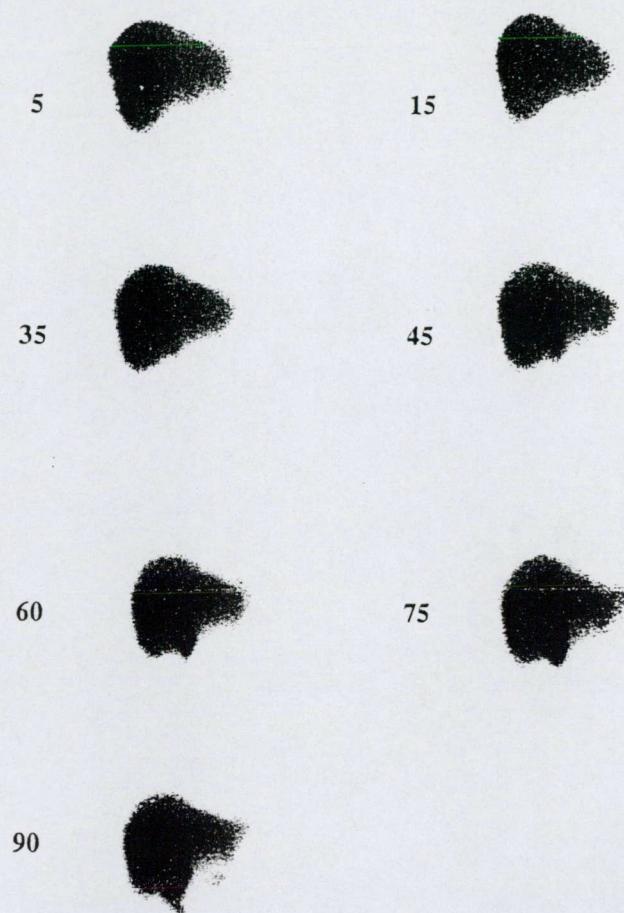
Hepatobiliary scintigram in a patient with a positive prostigmine-morphine test and SO spasm. Note the marked accumulation of the isotope in the biliary tree, which persisted until the end of the study. No bowel activity appeared until 60 min
